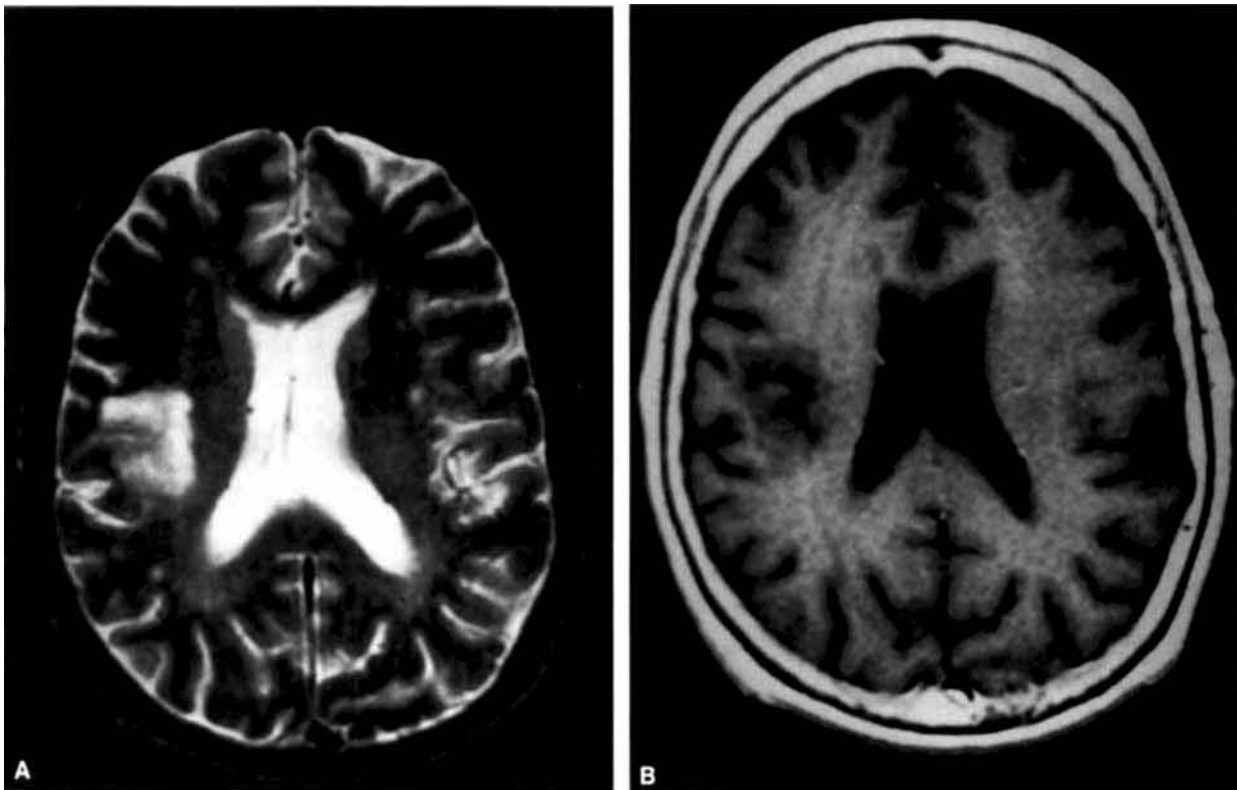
(A) T2-weighted (TR 2500; TE 90) axial MR image of head, 1 month after discontinuation of 5-FU and levamisole therapy, revealing diminution in volume of the focus of corona radiata T2 hyperintensity. (B) T1-weighted (TR 600; TE 90) axial MR image with intravenous gadolinium reveals resolution of the previously noted peripheral ring-type enhancement.
